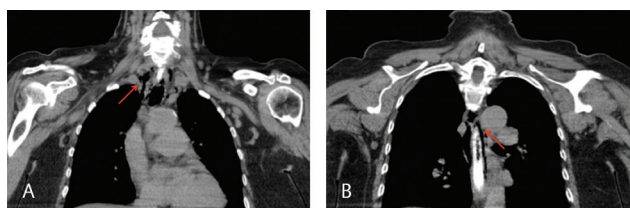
(A, B) One day after the perforation, CT showed a leakage in the proximal esophagus with proof of air and suspicion of contrast media in the mediastinum.
